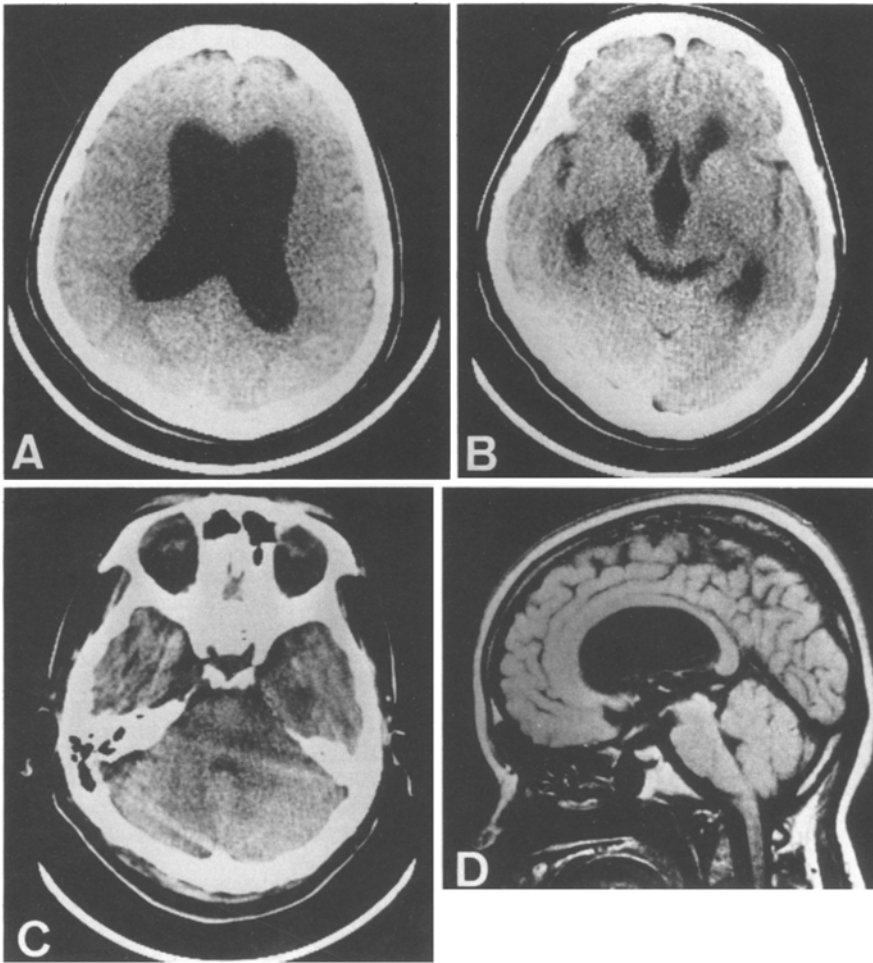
Computed tomographic scan (A–C) and magnetic resonance imaging (D) of this patient. Note marked dilatation of the lateral (A) and the third (B) ventricles and the normal size of the fourth ventricle (C). Part of the aqueduct of Sylvius is obscure (D)
